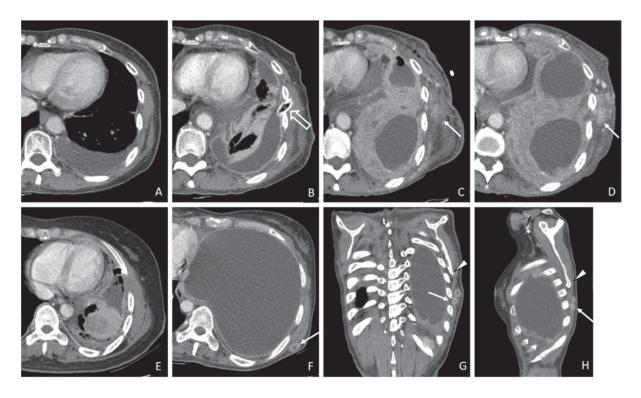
Enhanced chest computed tomography (CT) scans of an advanced stage lung cancer patient with pleural effusion who underwent intercostal chest drainage (ICD) and percutaneous catheter drainage insertions as well as thoracocentesis and pleural biopsy at initial scan (A) and follow-up scans which show progression of the disease (B-D). The ICD is observed (open arrow). After ICD removal, 2- (C) and 5-month (D) follow-up CT images show developed and growing enhanced chest wall nodules along the route of the removed ICD (arrows in C-D). Enhanced chest CT scans of another patient who underwent thoracocentesis and pleural biopsy at diagnosis (E) and 9 months later after the procedure (F-H). Note the large amount of left pleural effusion with two circumscribed heterogeneously enhanced nodules at the left posterior chest wall (arrows in F-H), just at the inferior tip of the scapula (arrowhead), which is a common location for a thoracocentesis or blind pleural biopsy.
